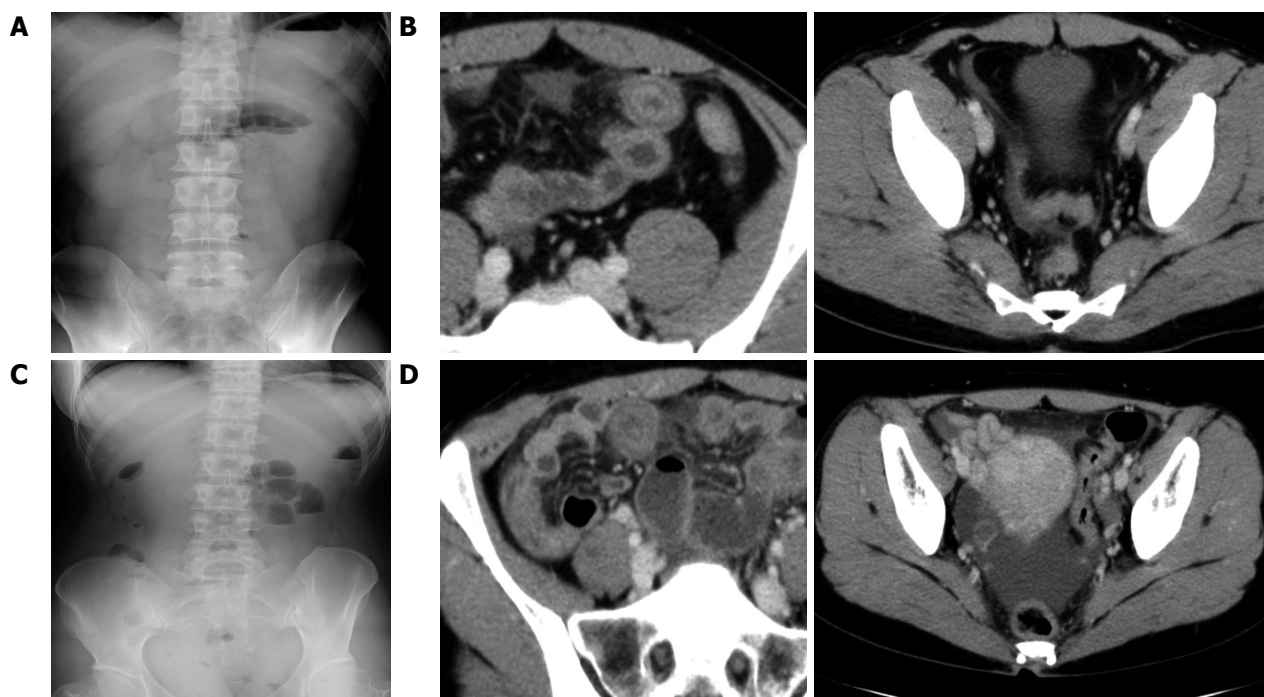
Abdominal X-ray (A, C) and computed tomography scan (B, D).
